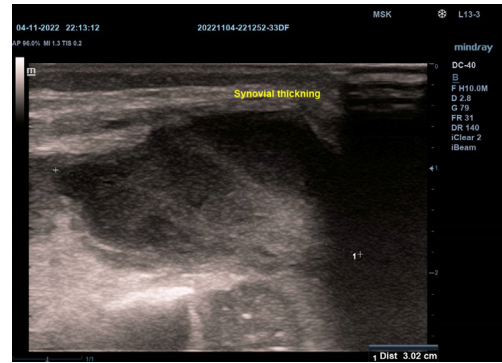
Knee ultrasound, sagittal scan. Synovial thickening.
